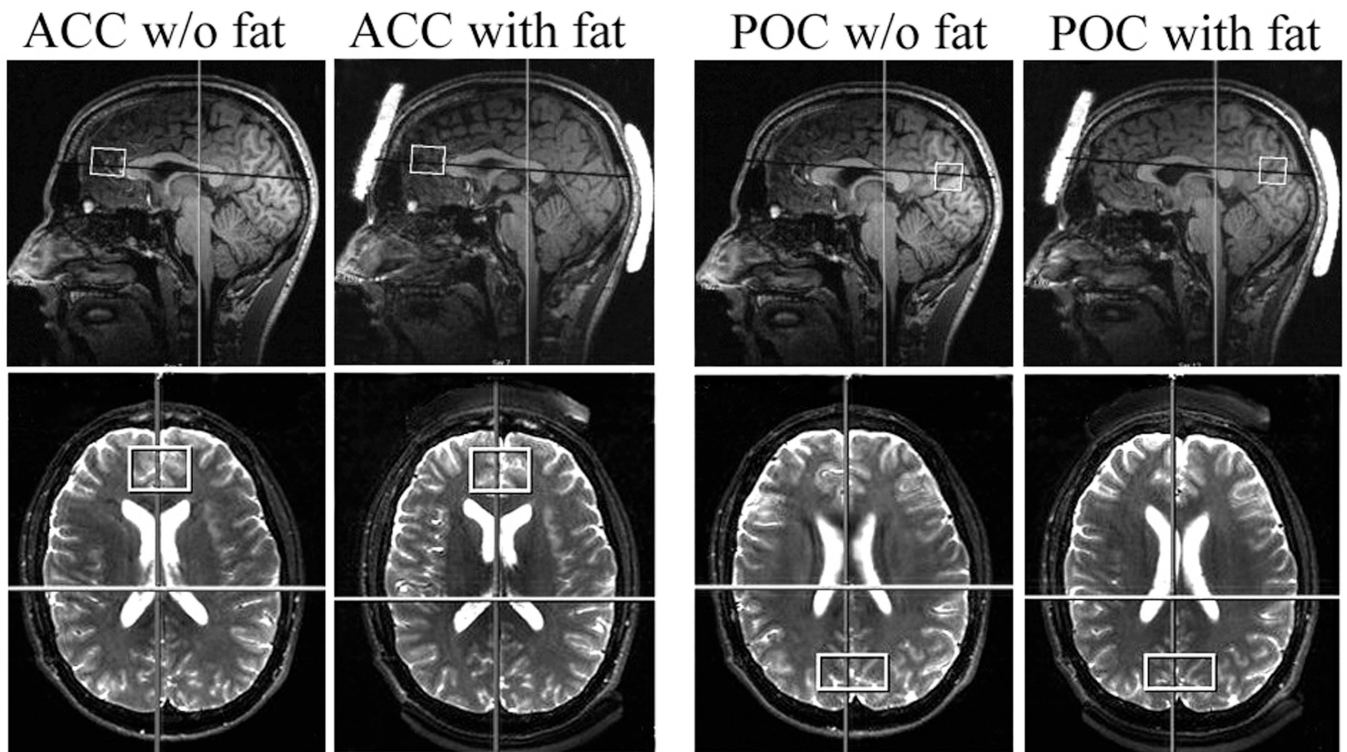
Sagittal T1-weighted (top) and axial T2-weighted (bottom) images showing the positions of the fat layers on the head and the VOIs in the brain from one *in vivo* experiment. Left panel: ACC (with and without fat layers), Right panel: POC (with and without fat layers).
